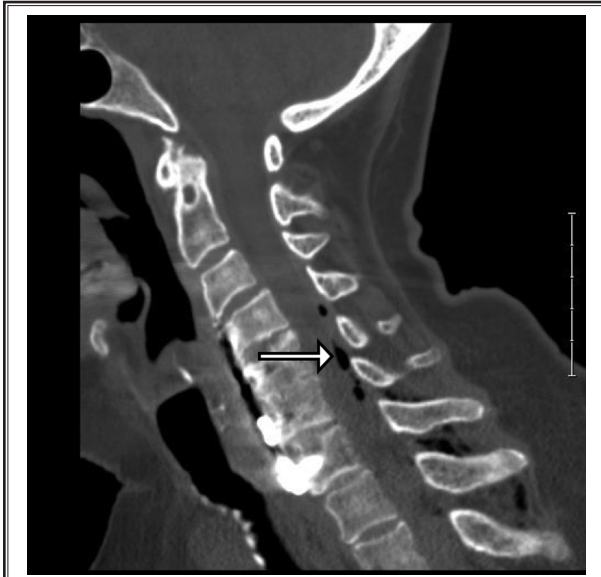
CT of the cervical spine, sagittal view. Arrow points toward epidural space air bubbles from C4-5 to C6-7. Multiple air bubbles outside of the spinal canal immediately adjacent to the right side of spine extend from C6-7 and T-2.
